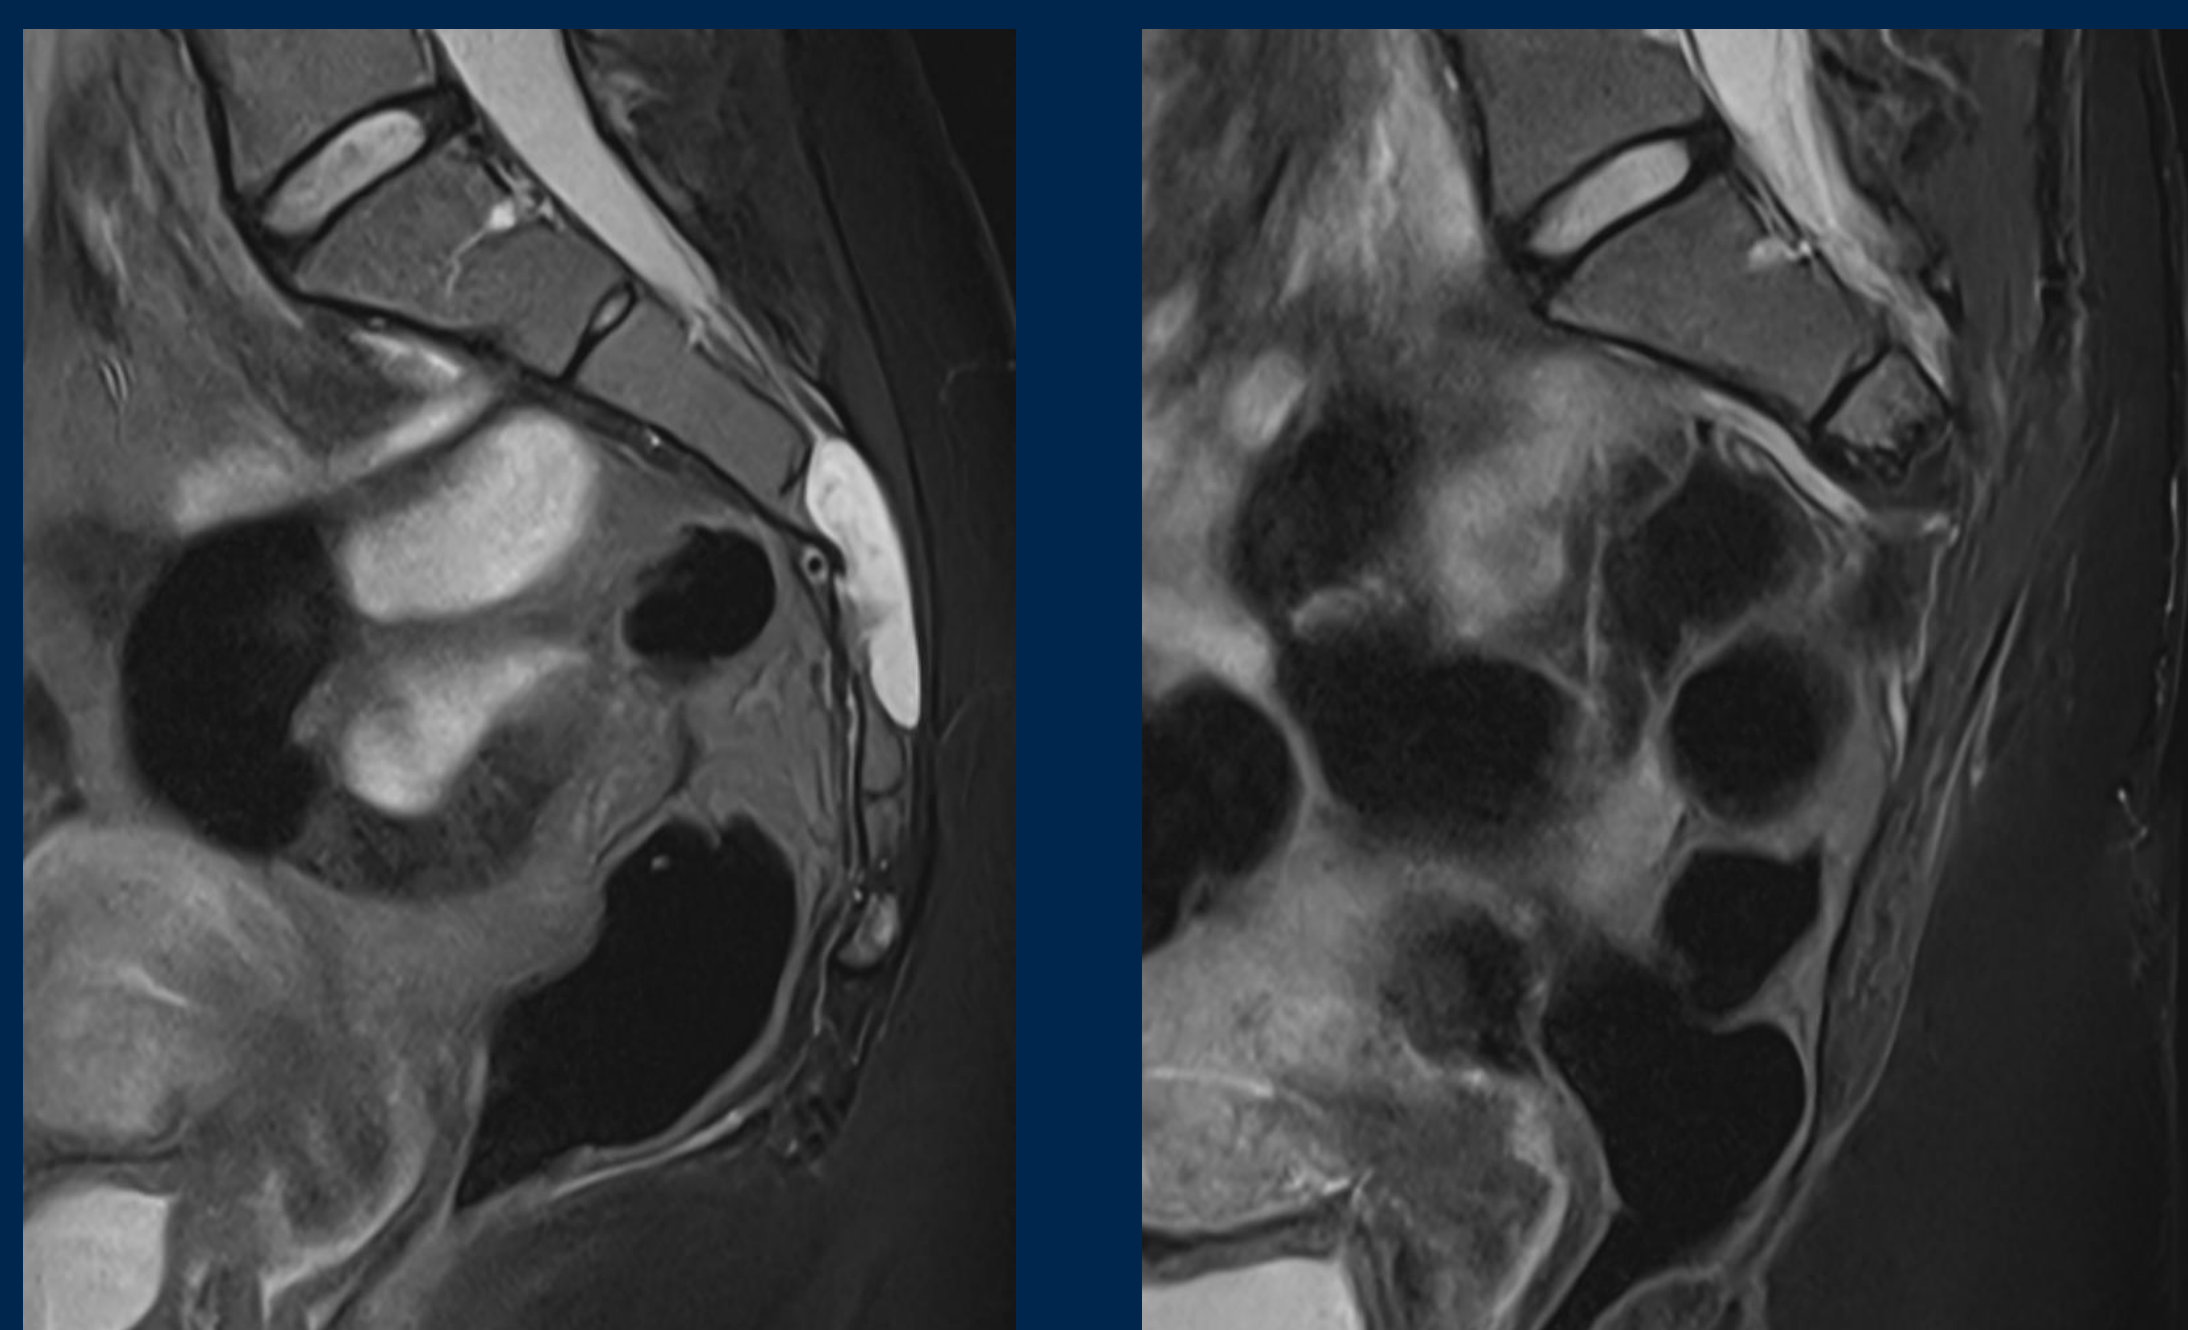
Sacrum MRI pre- and postoperatively in lateral view
